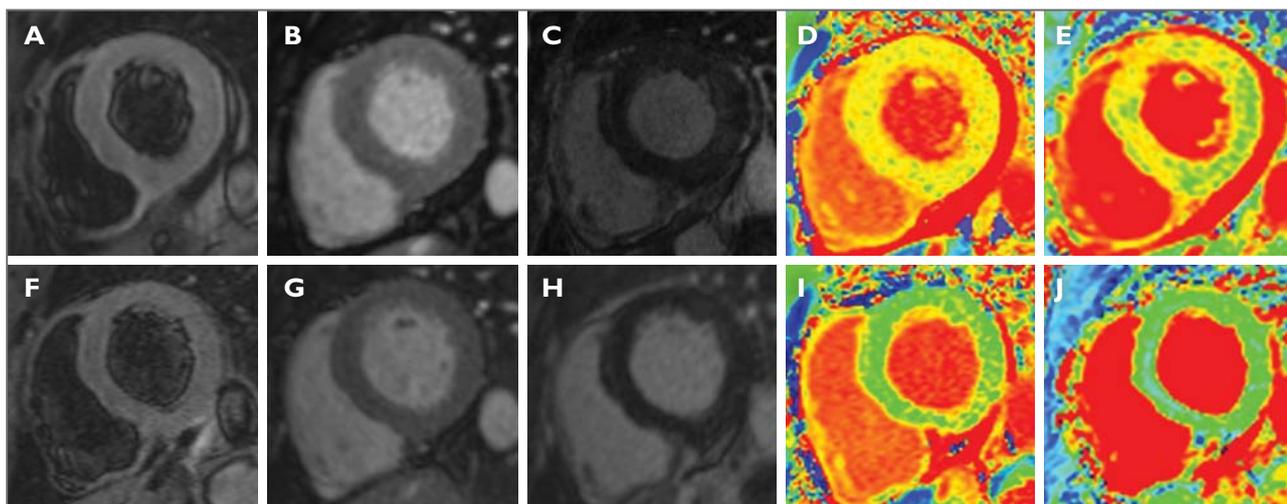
Cardiac magnetic resonance imaging (CMR) performed during initial presentation (top row) and at follow up 1 month after diagnosis (bottom row). (A) Short tau inversion recovery (STIR) sequence showing increased signal throughout the left ventricle (LV) in keeping with diffuse active myocardial oedema. (B) and (C) The absence of both early and late gadolinium enhancement (EGE/LGE) meant that the classic Lake Louise diagnostic criteria for acute myocarditis was not fulfilled. (D) and (E) Parametric myocardial mapping showing both increased T1 and T2 relaxation times (yellow/red areas) in keeping with active myocardial oedema. These parameters were added to the 2018 update of the Lake Louise criteria to improve specificity and diagnostic accuracy of CMR in myocarditis. (F) Repeat CMR 1 month after diagnosis showing complete resolution of myocardial oedema on STIR imaging. Note also the reduction of LV wall thickness. (G) and (H) EGE and LGE remained absent at follow up. (I) and (J) Parametric myocardial mapping showed normalisation of both T1 and T2 relaxation times (green/blue areas) in keeping with resolution of myocardial oedema.
